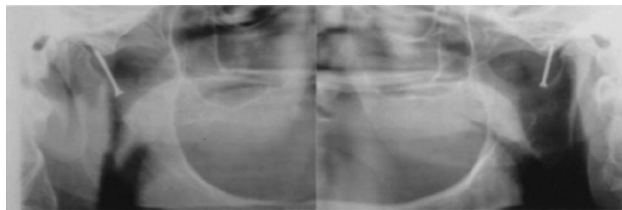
Anteroposterior radiograph reveals two screws fixed on articular eminences.
